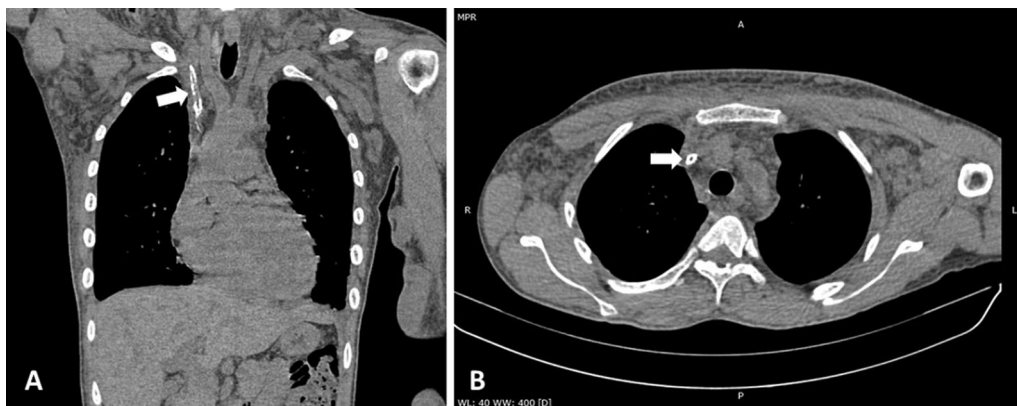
Unenhanced coronal and axial CT scan of the thorax showing a hyperdense linear tubular structure (white arrows) measuring approximately 6.2 cm in length within the right brachiocephalic vein extending to the superior vena cava (SVC), which at first glance was concerning for a retained catheter fragment. However, the discontinuous and interrupted appearance of this hyperdense structure, with a visible lumen suggested a calcified fibrin sheath instead
